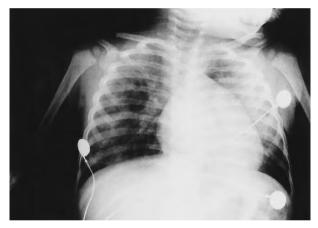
Chest radiograph showing right lung interstitial infiltrates and left lung consolidation in an 18-month-old child with AIDS and *Pneumocystis carinii* pneumonia.
